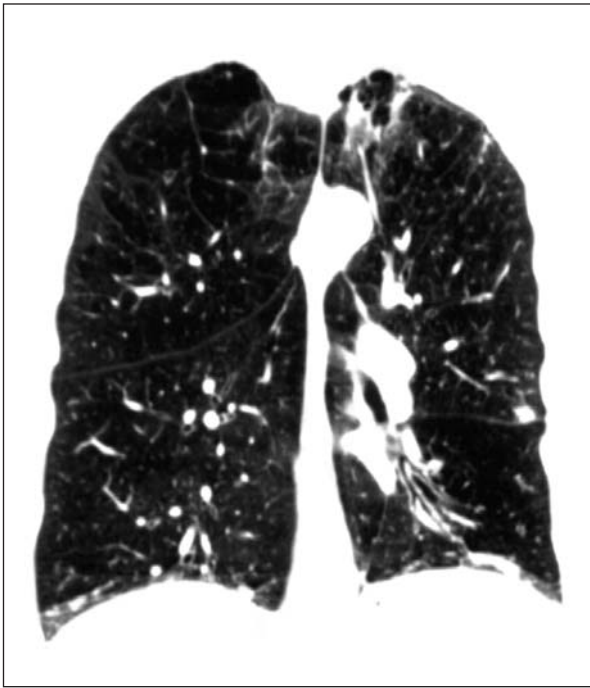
Chest CT coronal section demonstrating left upper lobe cavitation on a background of severe emphysema.
